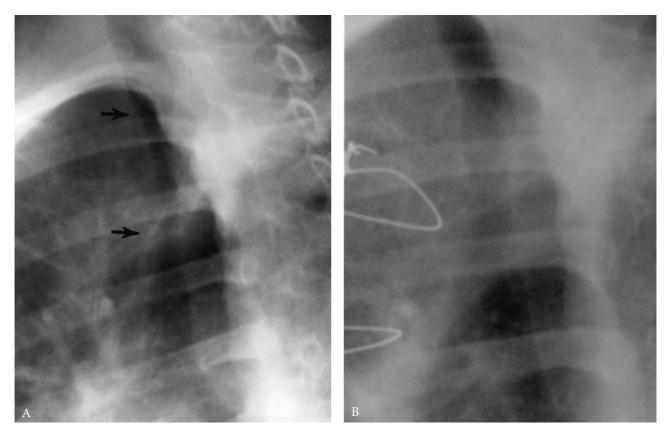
Imaging of congenital tracheal stenosis in an 11-year-old boy. A, The simple oblique roentgenogram shows the location (arrow) and length of stenosis as well as the length of normal trachea from larynx to carina—all critical information for the surgeon. B, Postoperative view of the same patient. Note the increased acuteness of the carinal angle.
